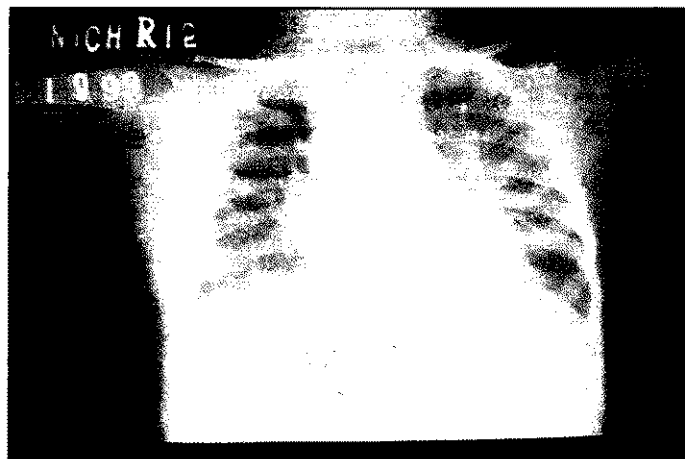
X-ray chest at discharge showing complete expansion of right lung following upper lobectomy.
